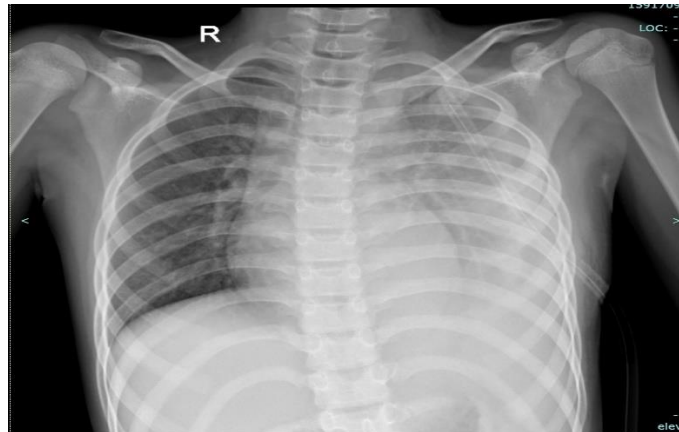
The chest X-ray demonstrates the left hemithorax with an indwelling chest tube, reduced lung expansion, and findings consistent with fluidopneumothorax.
